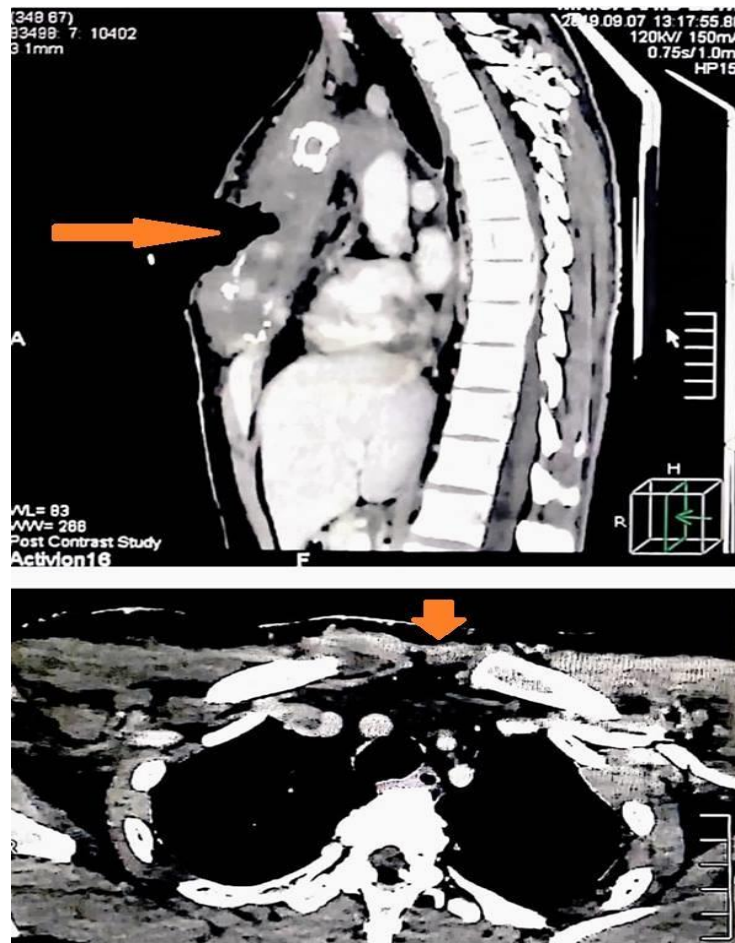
Chest CT scan sagittal and axial views showing anterior chest wall defect in both views
